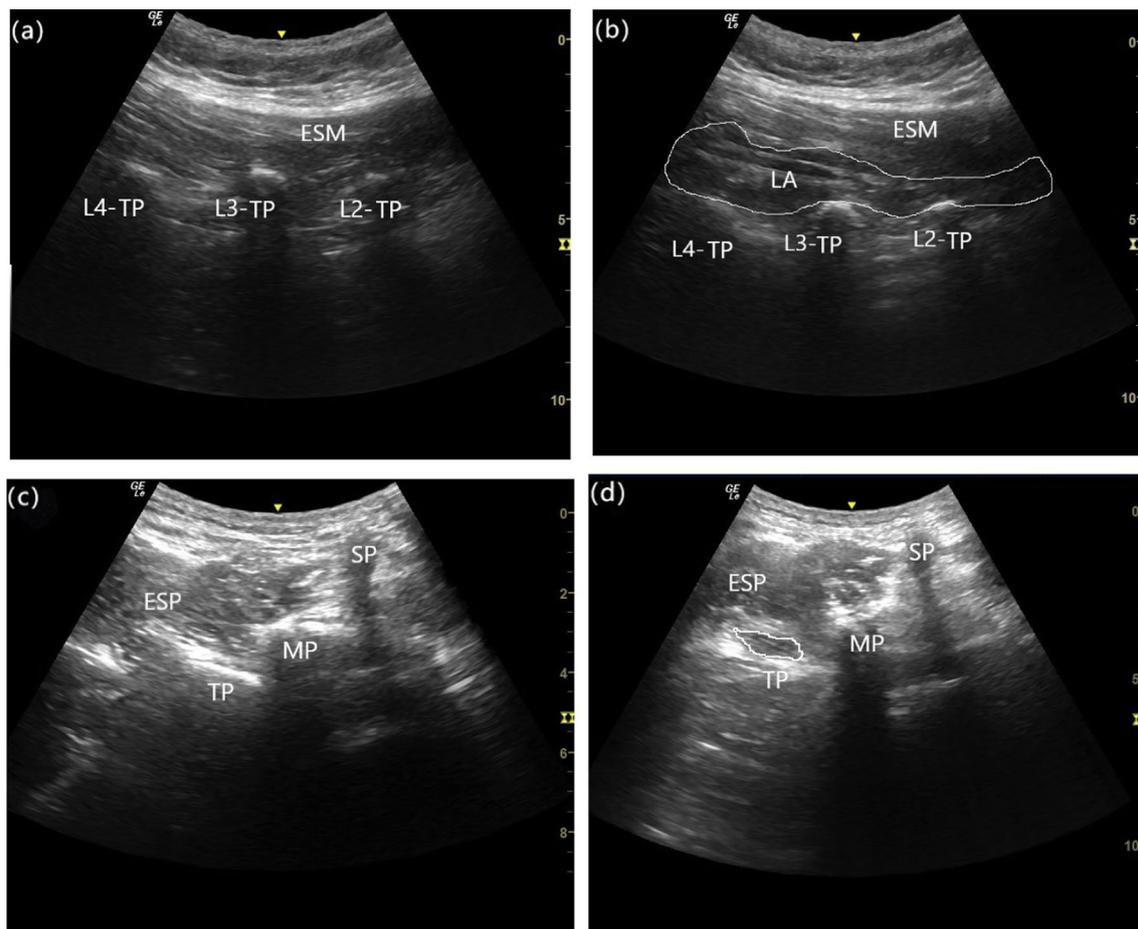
Sonographic anatomy of the erector spinae plane (A, longitudinal; C, transverse) and erector spinae plane block (B, out-of-plane approach longitudinally; D, in-plane approach transversely). The area
